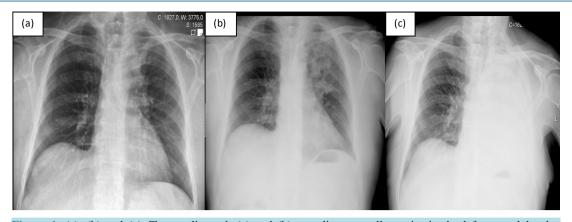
(a), (b) and (c) Chest radiograph (a) and (b) revealing a small opacity in the left upper lobe that progressed to an extensive opacification with multiple air levels, previously to surgery. Chest radiograph (c) after surgery.
